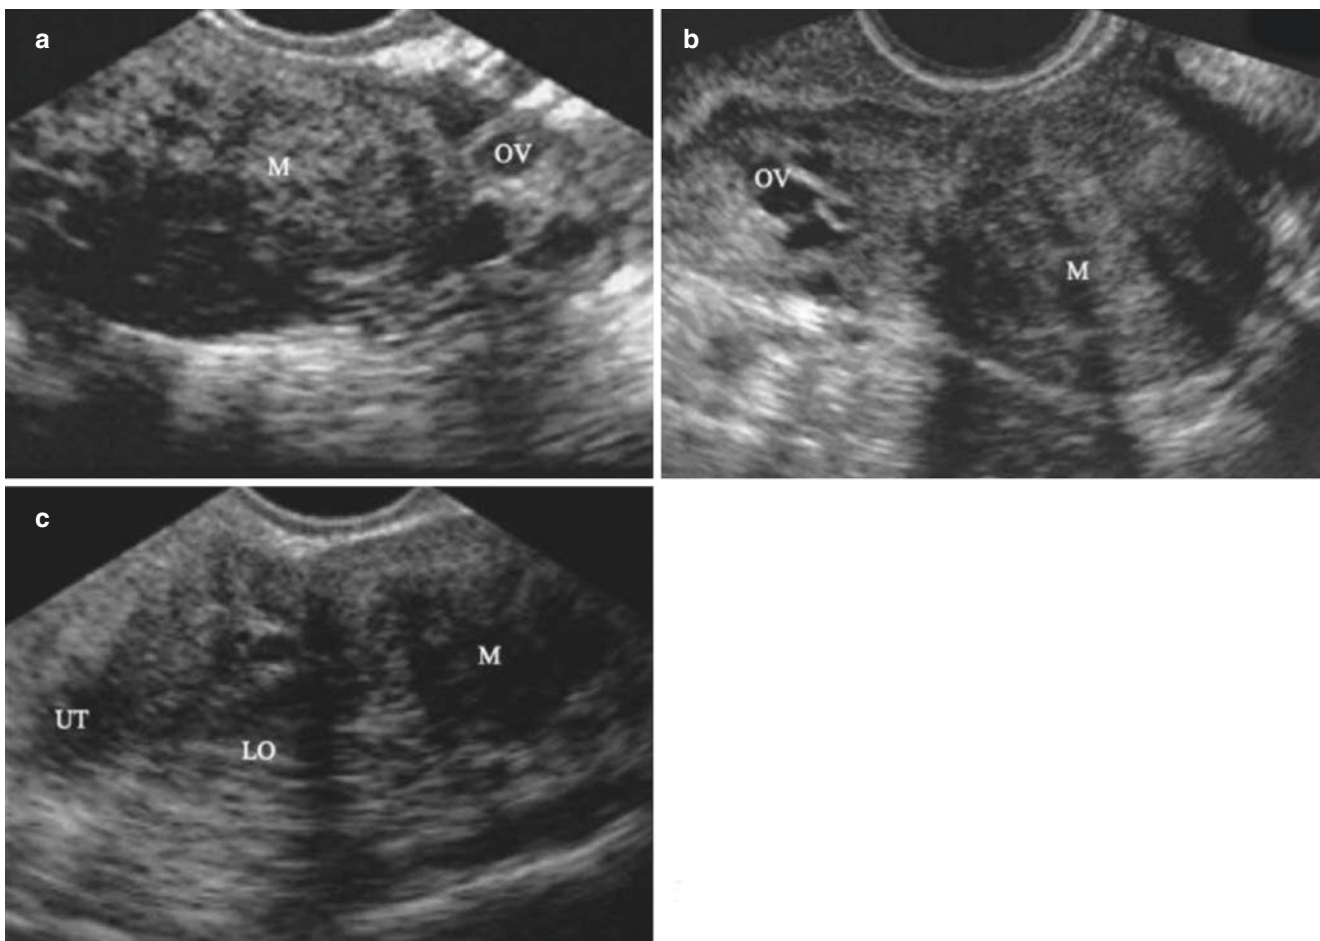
Leiomyoma (X). (a, b) Sonogram shows the subserosal fibroid in the annex area and ipsilateral ovary. (c) Sonogram shows the fibroid within the broad ligament, with a certain distance from the uterus. The ipsilateral ovary is visible
